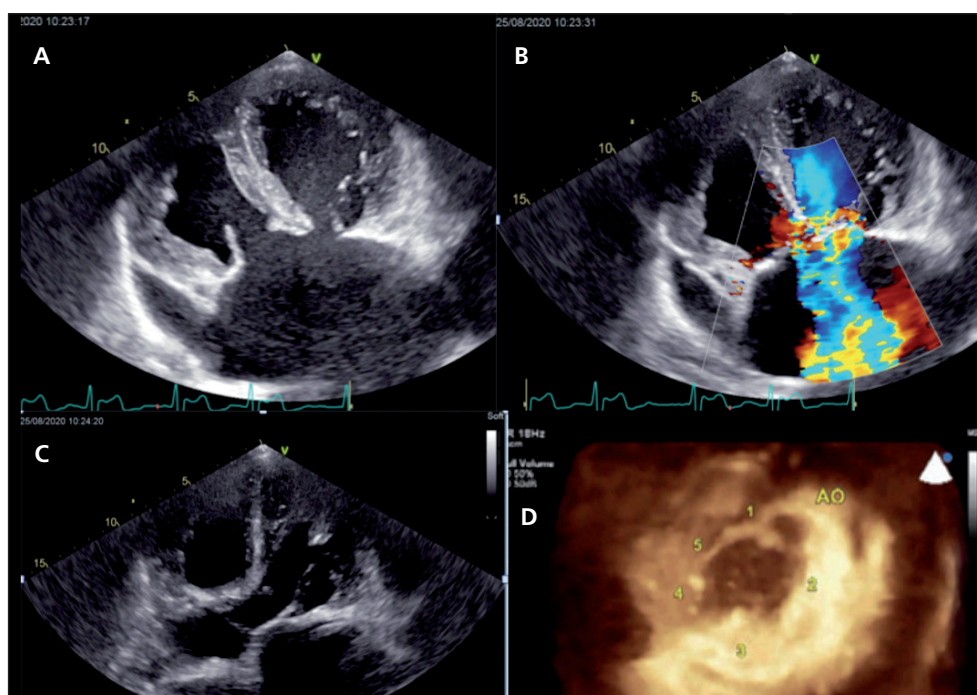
(A) 2D-TT echocardiography, apical view demonstrating a CAVC picture. (B) 2D-TT echocardiography, apical view, colour Doppler mode demonstrating massive regurgitation jets through common AV valve. (C) 2D-TT echocardiography, apical view, demonstrating left ventriculo-arterial concordance. (D) RT-3D-TT echocardiography: en face view of the common AV valve showing all five leaflets.
